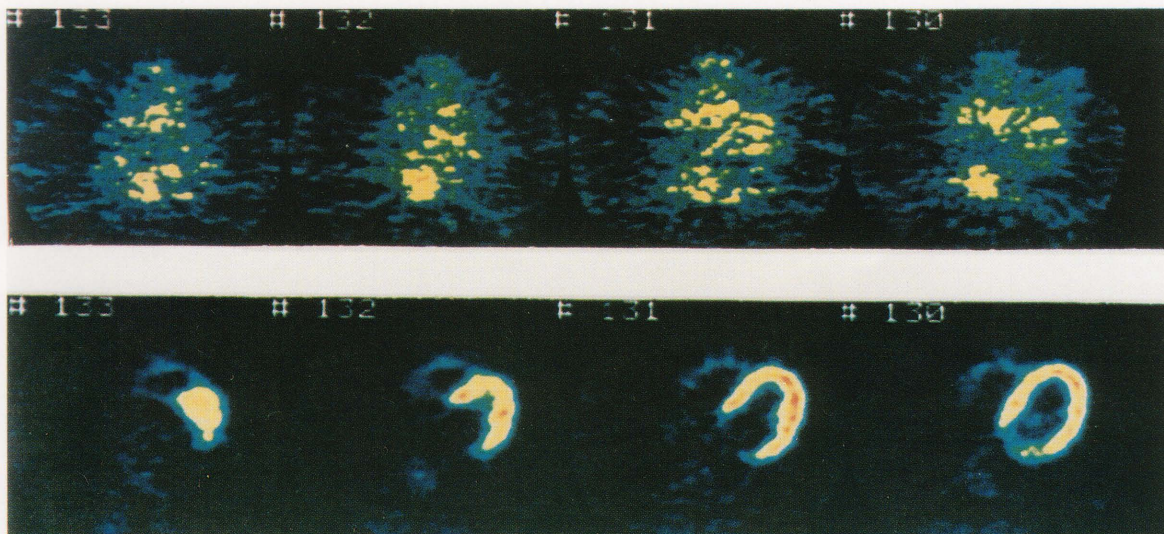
Representative ^{18}F FDG-PET images obtained during fasting and glucose loading in a normal volunteer. This subject had a fasting plasma glucose level of 94 mg/dl, and a plasma glucose level of 140 mg/dl after glucose loading.
